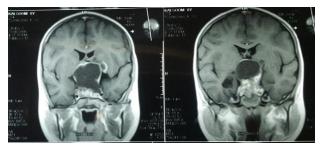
MRI Brain showing coronal view of craniopharyngioma
